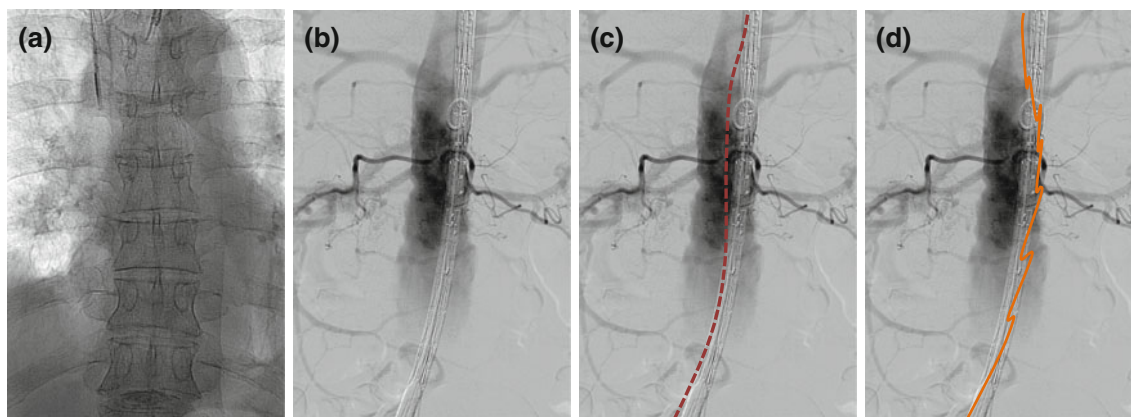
An example of the X-ray images seen during an endovascular procedure: a with no contrast, the soft tissue and vessels cannot be seen. b With contrast agent, a roadmap of the vessels (here the aorta) is produced. c The optimal path (*red*) for the catheter to travel can be
